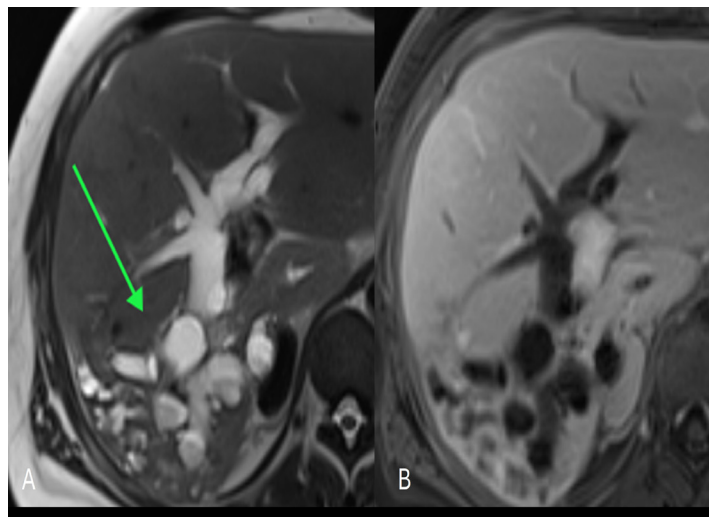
MRI abdomen with and without contrast. (A) Axial T2 image demonstrates marked intrahepatic biliary ductal dilatation (arrow) in the posterior right hepatic lobe from IPNB; (B) Axial postcontrast T1 fat saturated image without enhancing intraductal mass or filling defect.
